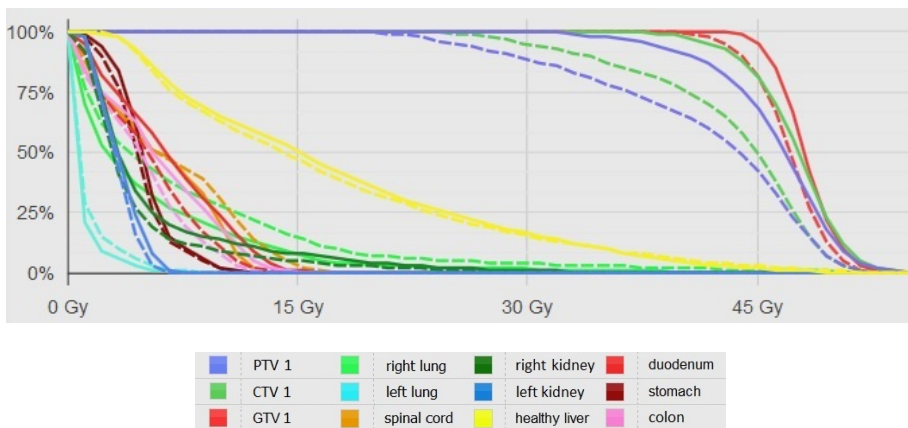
DVHs for 3D dose distribution calculated by MCS on the 4D_Ph1 CT images (solid line) and 3D dose distribution calculated by MCS on the 4D_Ph3 CT images (dashed line), for patient 4 GTV1
